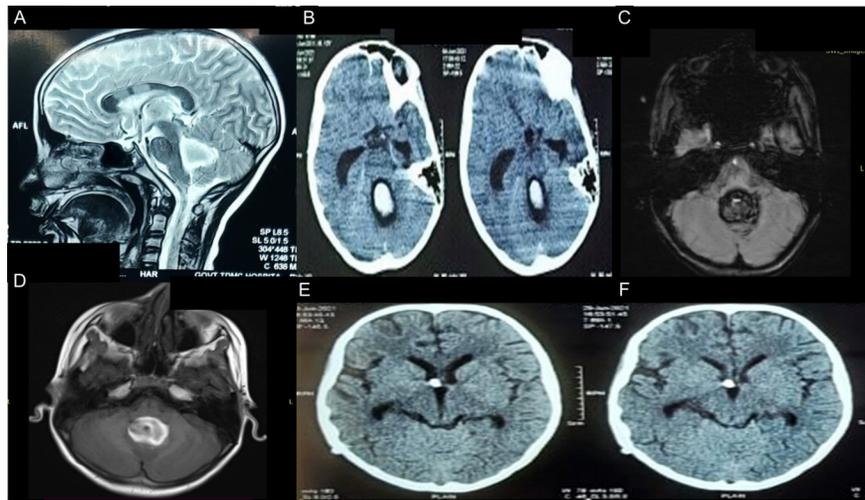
MRI showing isolated hemorrhage in the 4th ventricle. 1B: CT scan showing a hyperdense area of blood density noted within 4th ventricle, likely Intraventricular hemorrhage. Upstream dilatation of bilateral lateral and 3rd Ventricle is noted, possibly due to obstructive hydrocephalus. 1C: Susceptibility Weighted Image showing blooming foci in the 4th Ventricle. 1D: T1 weighted image showing hyperintense area within 4th Ventricle. 1E, F: CT scan taken after VP shunt showing EVD tube in situ with tip in the right lateral ventricle. Mild hydrocephalus (reduced) seen.
